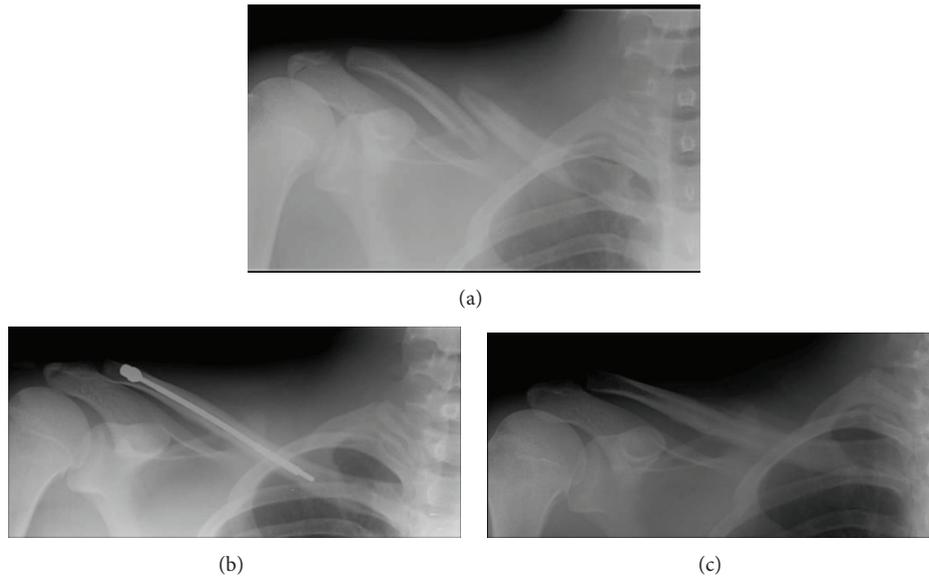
(a) AP radiograph of the clavicle showing a midshaft clavicle fracture with displacement and 2.3 cm shortening. (b) Postoperative radiograph of the same patient after fracture fixation using the Rockwood clavicle. (c) Followup radiograph taken 3 months postoperatively after fracture union and removal of the Rockwood clavicle pin.
